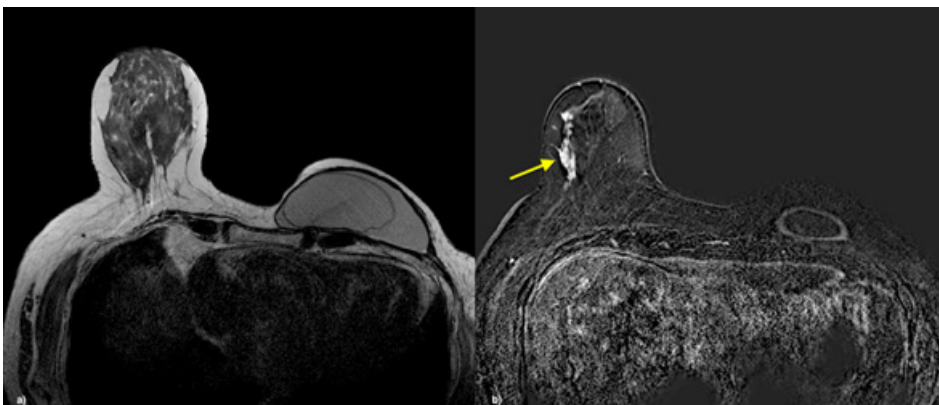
A 71-year-old woman with a history of breast carcinoma on the left with breast reconstruction with a *Latissimus dorsi* flap and implant. In the MRI study, the presence of intracapsular rupture on the right was verified, identifying the signal of the subcapsular line (a). In the dynamic study after administration of contrast (b), a non-mass enhancement of the linear type was identified in the inferolateral quadrant of the contralateral breast, which after biopsy revealed a ductal carcinoma in situ.
